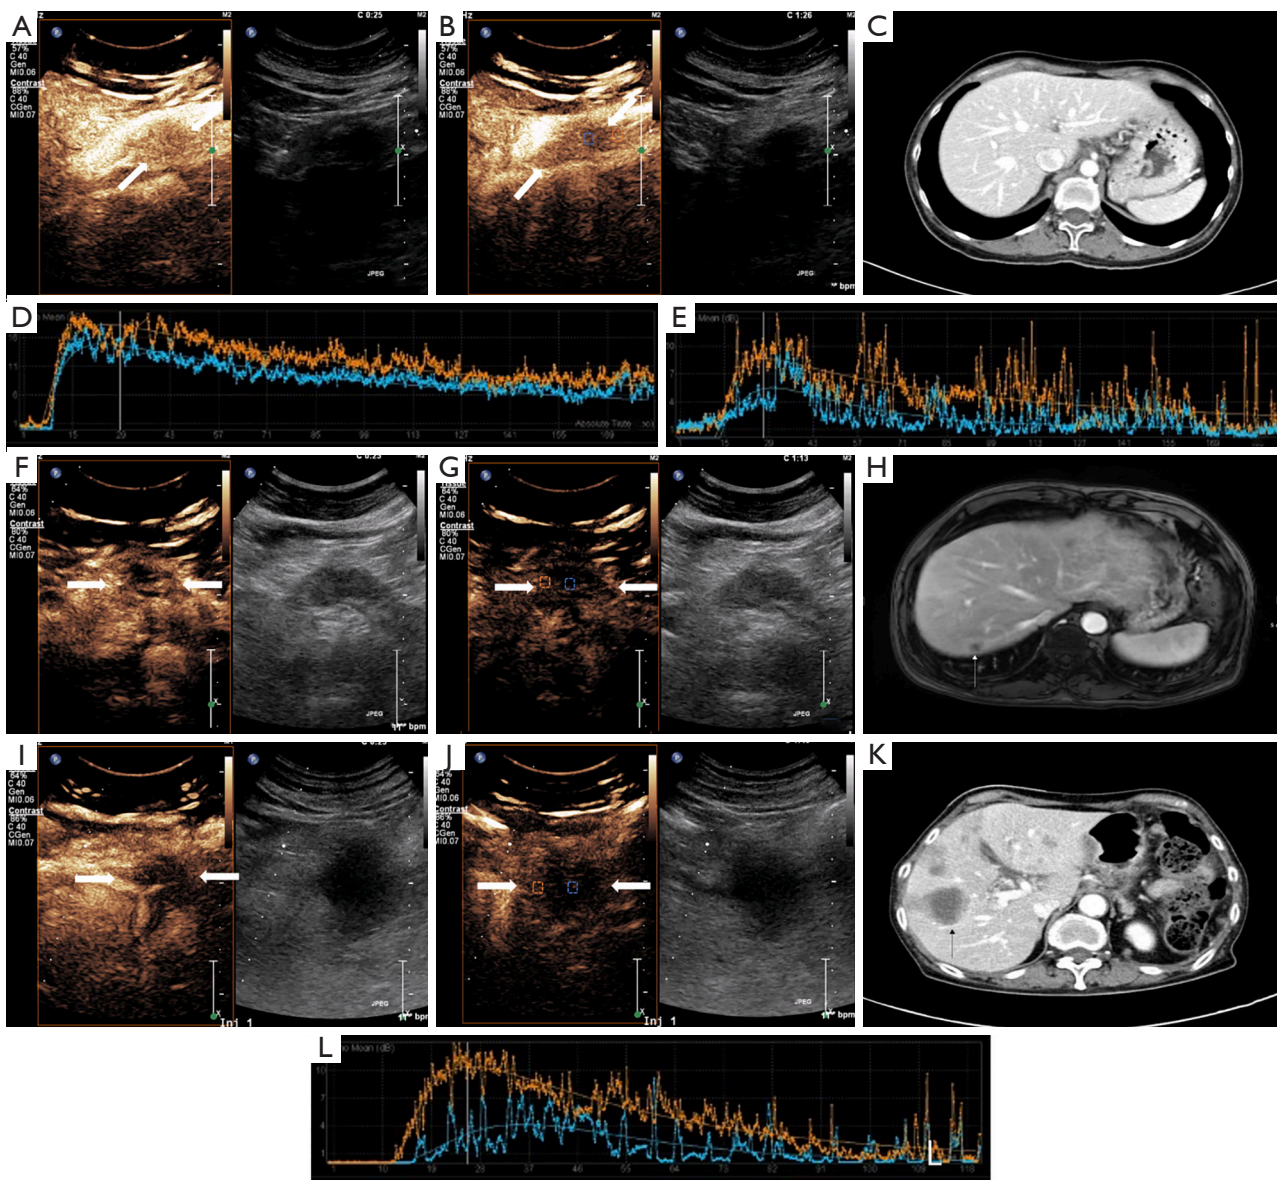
CEUS images of blood supply mode and parameters of PDAC in different hepatic metastasis groups. (A-D) A 56-year-old female with PDAC in the NHM group. Arterial phase (A) and late phase (B) of rich blood supply mode CEUS images. (C) CECT image showing no metastases in the liver. (D) TIC image with a WIS ratio of 0.88 and a PI ratio of 0.72. (E-H) A 70-year-old female with PDAC in the MHM group. Arterial phase (F) and late phase (G) of rich blood supply mode CEUS images. (H) CE-MRI image showing metachronous metastases in the liver (thin white arrow). (E) TIC image with a WIS ratio of 0.60 and a PI ratio of 0.62. (I-L) A 54-year-old male with PDAC in the SHM group. Arterial phase (I) and late phase (J) of rich blood supply mode CEUS images. (K) CECT image showing synchronous metastases in the liver (thin black arrow). (L) TIC image showing a WIS ratio of 0.42 and a PI ratio of 0.41. (A,B,F,G,I,J) The lesion is marked by a white arrow. (B,G,J) The blue dashed box shows the placement of the ROI in the center of the lesion, and the orange dashed box shows the placement of the ROI around the lesion. CEUS, contrast-enhanced ultrasound; PDAC, pancreatic ductal adenocarcinoma; NHM, negative hepatic metastasis; CECT, contrast-enhanced computed tomography; TIC, time-intensity curve; WIS, wash-in slope; PI, peak intensity; MHM, metachronous hepatic metastasis; CE-MRI, contrast-enhanced magnetic resonance imaging; SHM, synchronous hepatic metastasis; ROI, region of interest.
